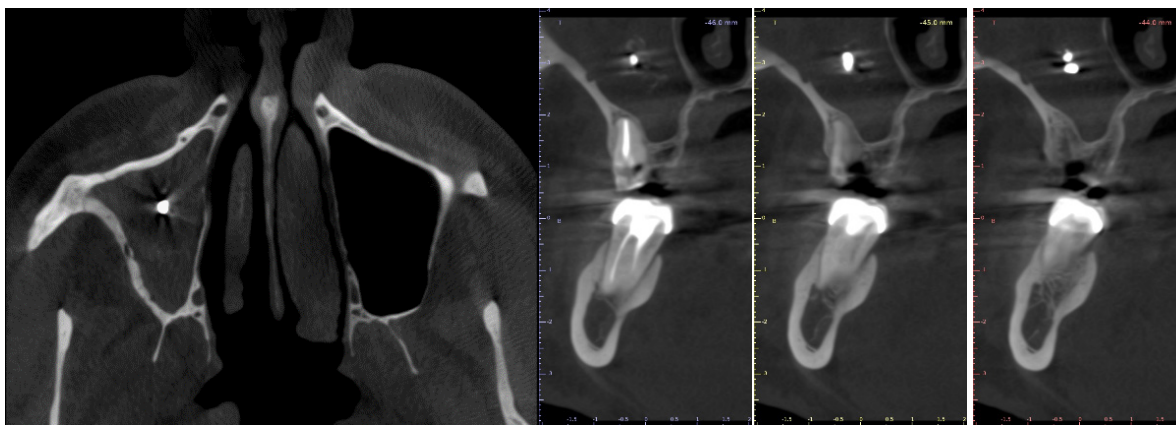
Computed tomography (CT) imaging a) axial image; b) cross-section images.
